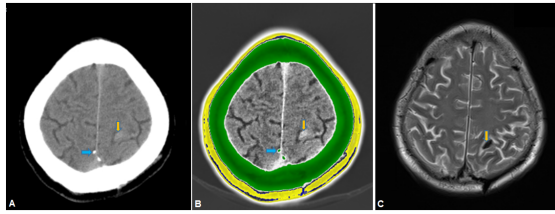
A small hemorrhagic lesion in left parietal lobe (yellow arrow) with tiny falx calcifications (blue arrow). (A) unprocessed grayscale CT image; (B) processed color CT image; (C) corresponding T2-weighted MRI scan.
